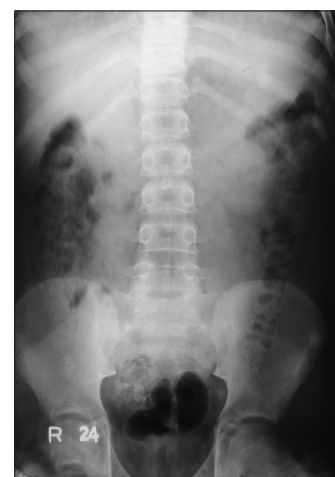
Anteroposterior abdominal radiograph showing no evidence of the anchorage screw in the abdominal cavity
